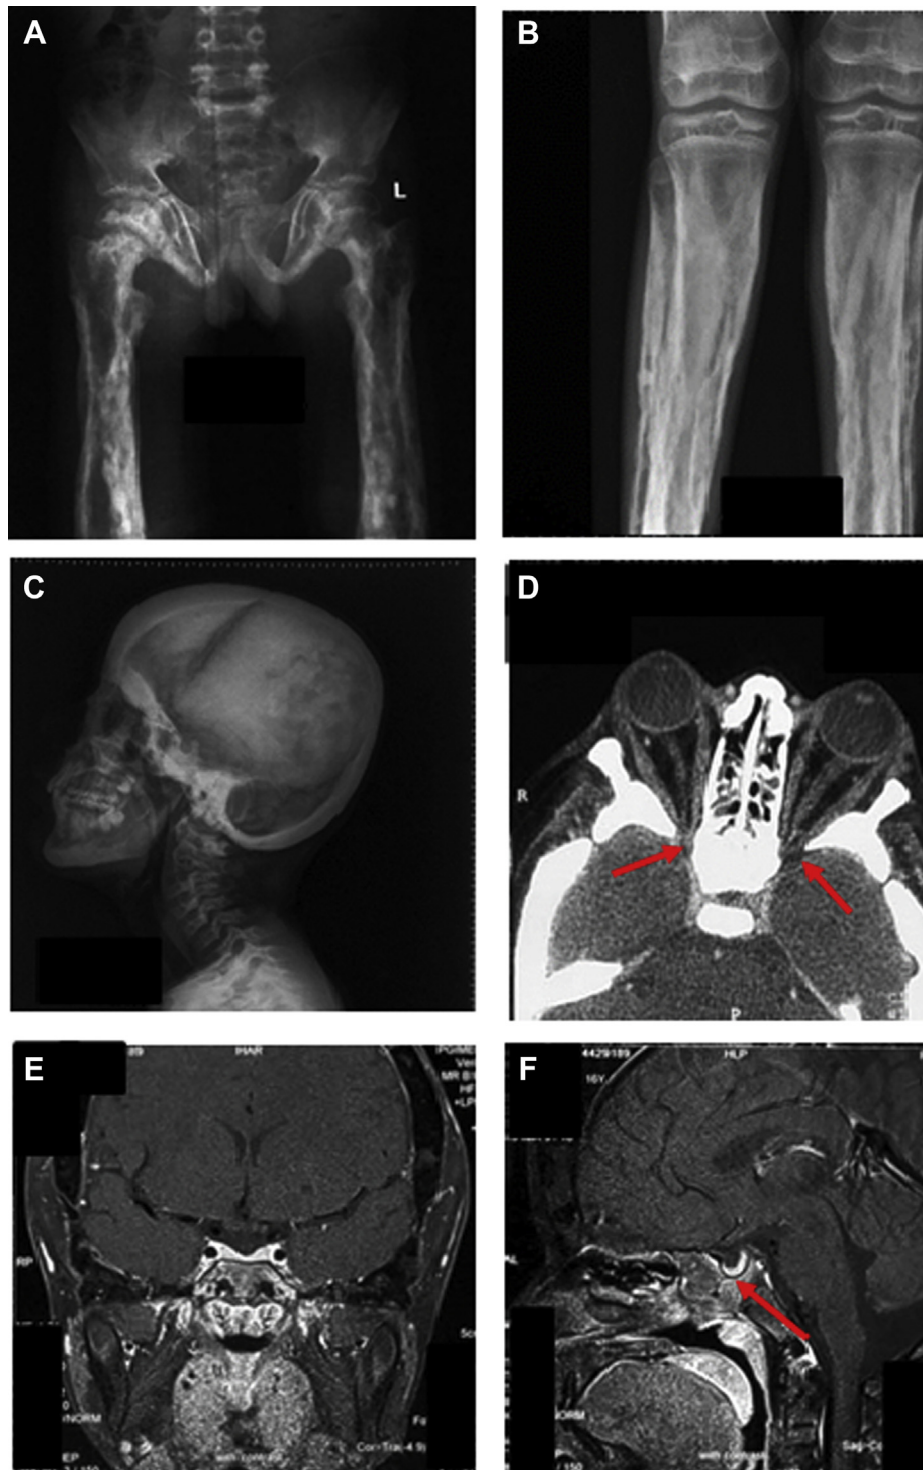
Panel of photographs. The top panel depicts the thickening and cortical sclerosis of the diaphysis of the long bones of the lower limbs on x-ray (A and B). The middle panel shows diffuse calvarial thickening and skull base osteosclerosis on lateral x-ray of the skull (C), and computed tomography head axial sections depict contracted optic canals bilaterally (red arrows) (D). The bottom panel shows typical flattening of the pituitary gland with partially empty sella on coronal (E) and sagittal (F) sections (red arrow) of gadolinium-enhanced magnetic resonance imaging as a consequence of intracranial hypertension due to skull base involvement.
